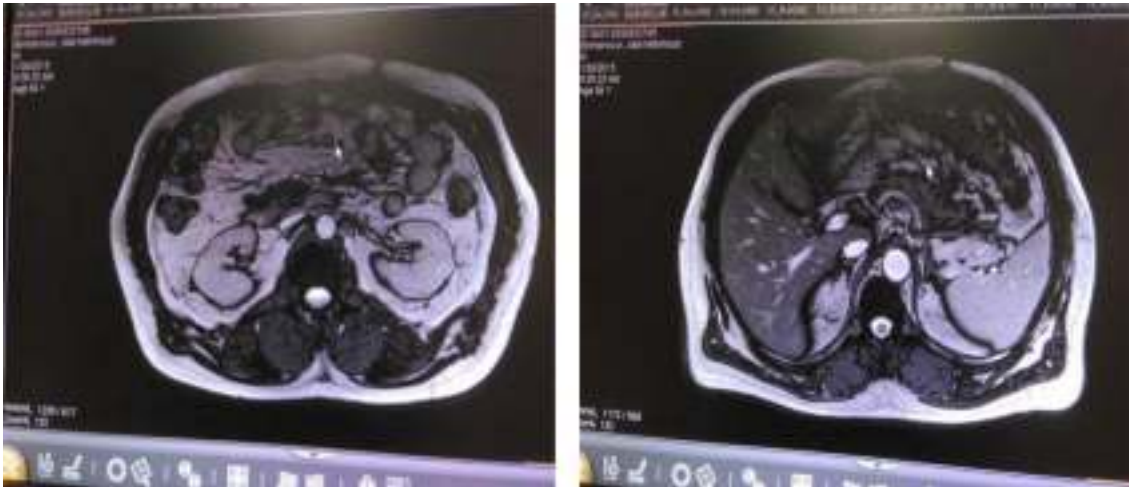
MRI GIST after treatment
